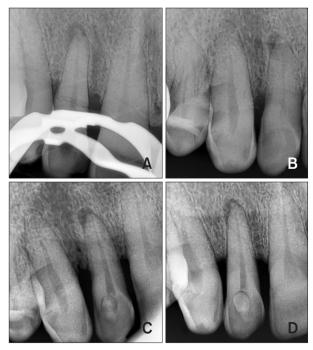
(A) A definite visualization of the horizontal root fracture (HRF) on the visit for canal filling. (B~D) Series of x-rays from different angles during the endodontic treatment were listed in chronological order. Still, the HRF was not quite visible. Several bony trabecular patterns and the superimposition of the alveolar bone crest level made it challenging to discriminate an HRF.
